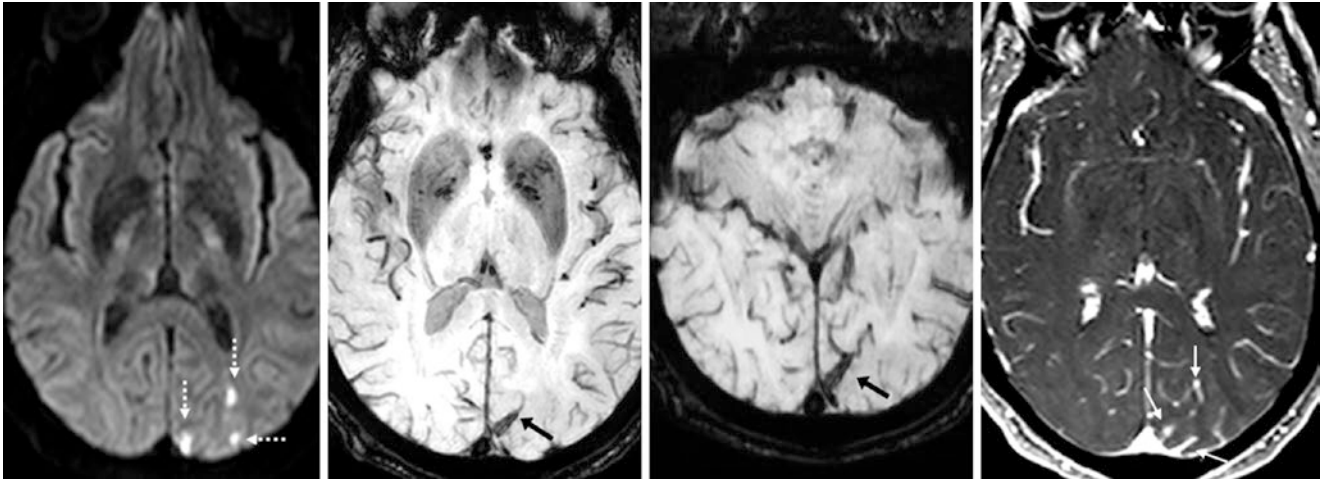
Comparison case of DVA associated with stroke. A 53 year old with acute visual symptoms underwent a 3T MRI, which demonstrated small occipital infarcts (*dotted arrows*) on DWI (*left*); within this region was an enlarged draining vein (*arrows*) from a DVA on 2-mm-thick axial SWI (*left middle*), which was better defined on 3-mm
